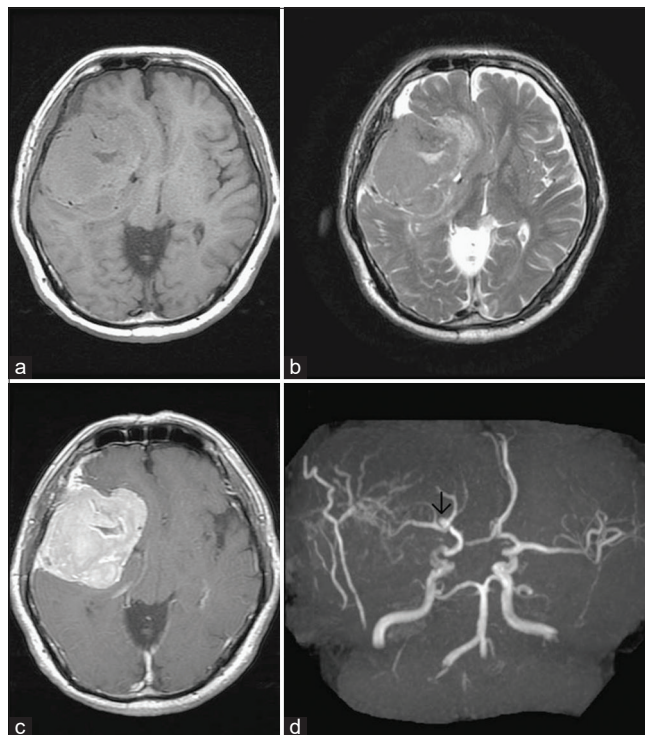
Preoperative brain MRI of case 7. Axial T1-weighted image (a) and axial T2-weighted image (b) showing a large extra-axial well-circumscribed mass lesion in the right frontal-temporal convexity, abutting the skull bone, isointense with cortical gray matter on both T1-weighted and T2-weighted image. Axial T1-weighted image postgadolinium enhancement (c) showing good enhancement. MRA (d) showing a small aneurysm in bifurcation of the right middle cerebral artery (black arrow).
